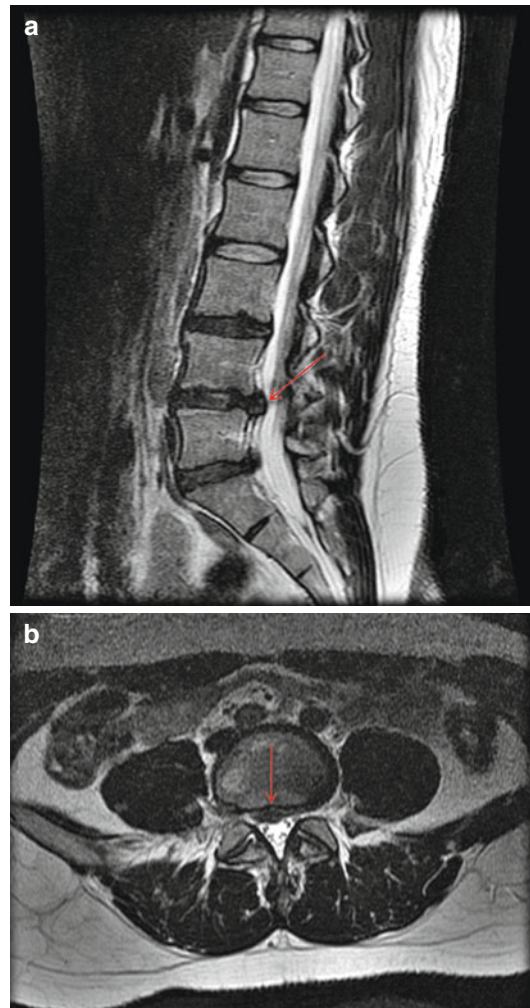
(a) Sagittal T2-weighted MRI scan of a 24-year-old female presenting with low back pain exacerbated with flexion. *Red arrow* denotes a central disc herniation at the L4–5 level. (b) Axial T2-weighted MRI scan with *red arrow* denoting the L4–5 central disc herniation without significant displacement or compression on the nerves. Nonoperative care was elected
